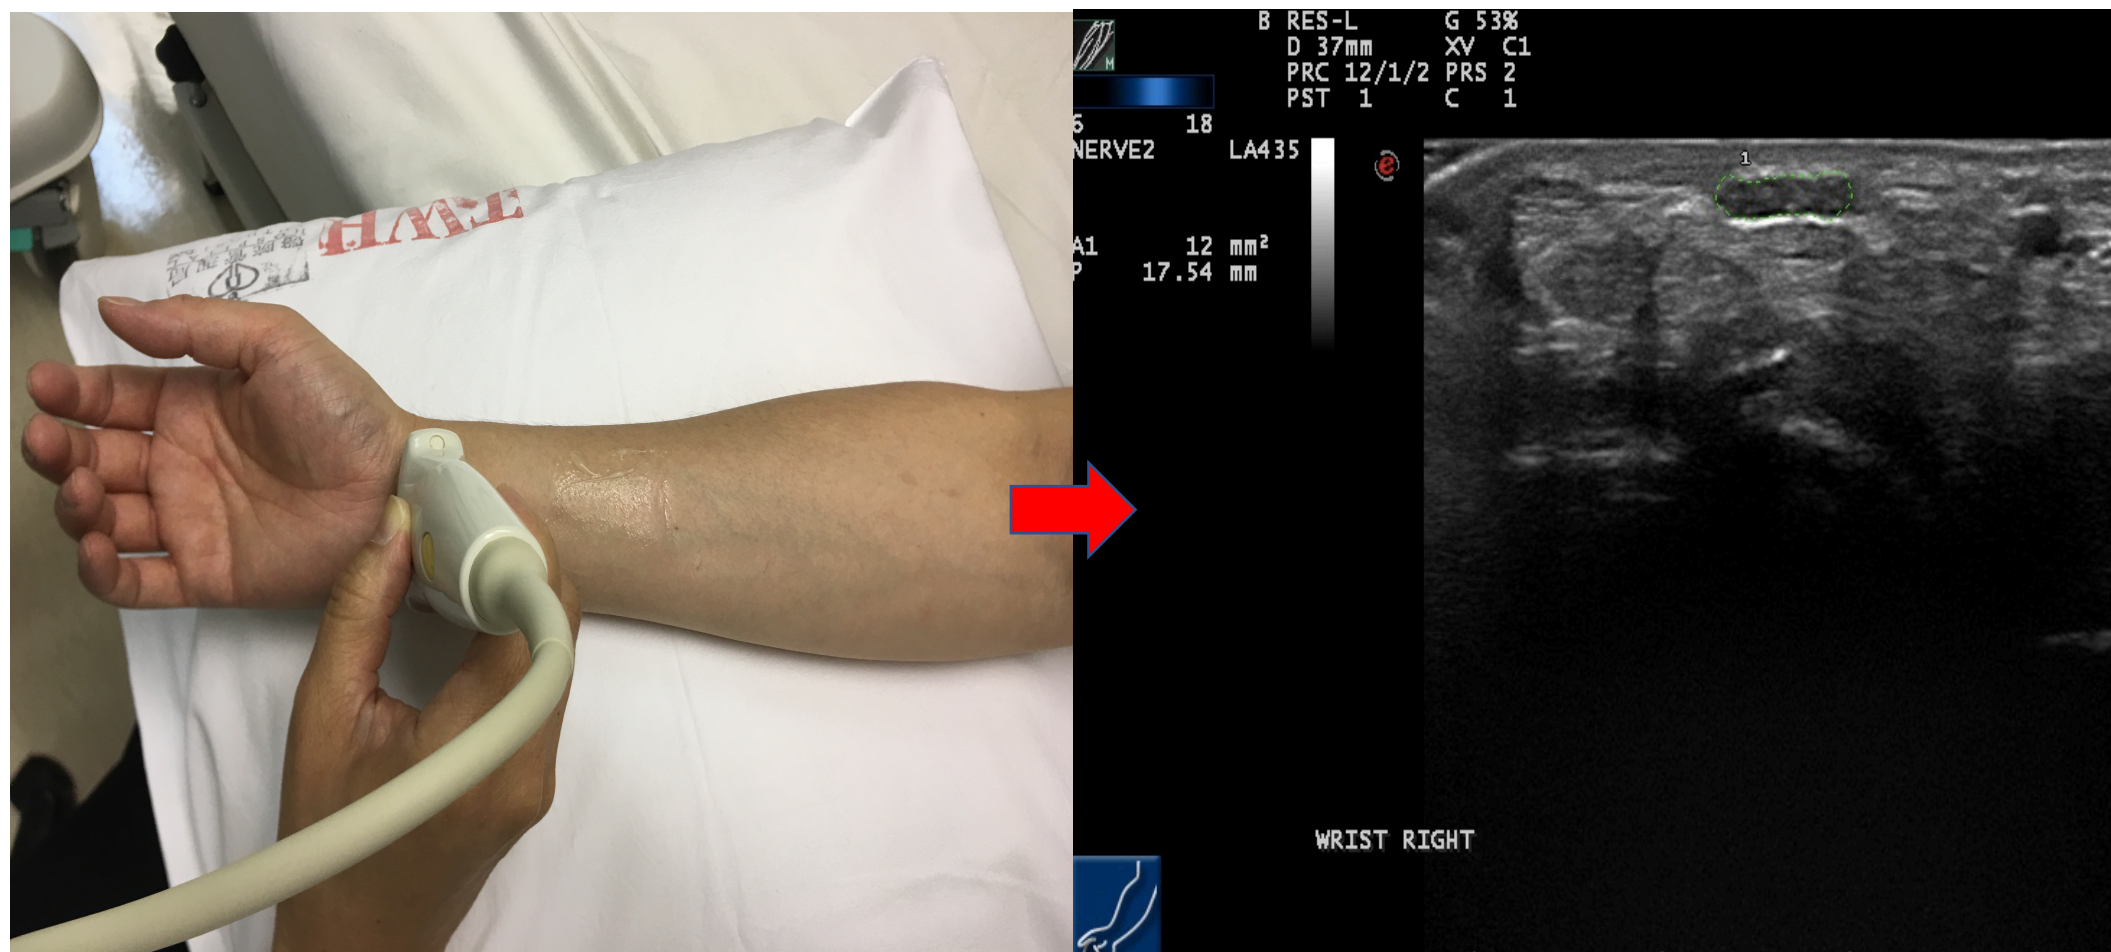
Measurement of the inlet of carpal tunnel and its ultrasound imaging
